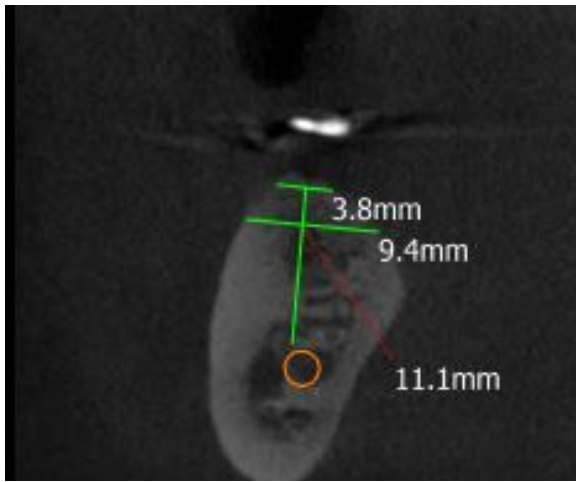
CBCT at the crest at baseline
